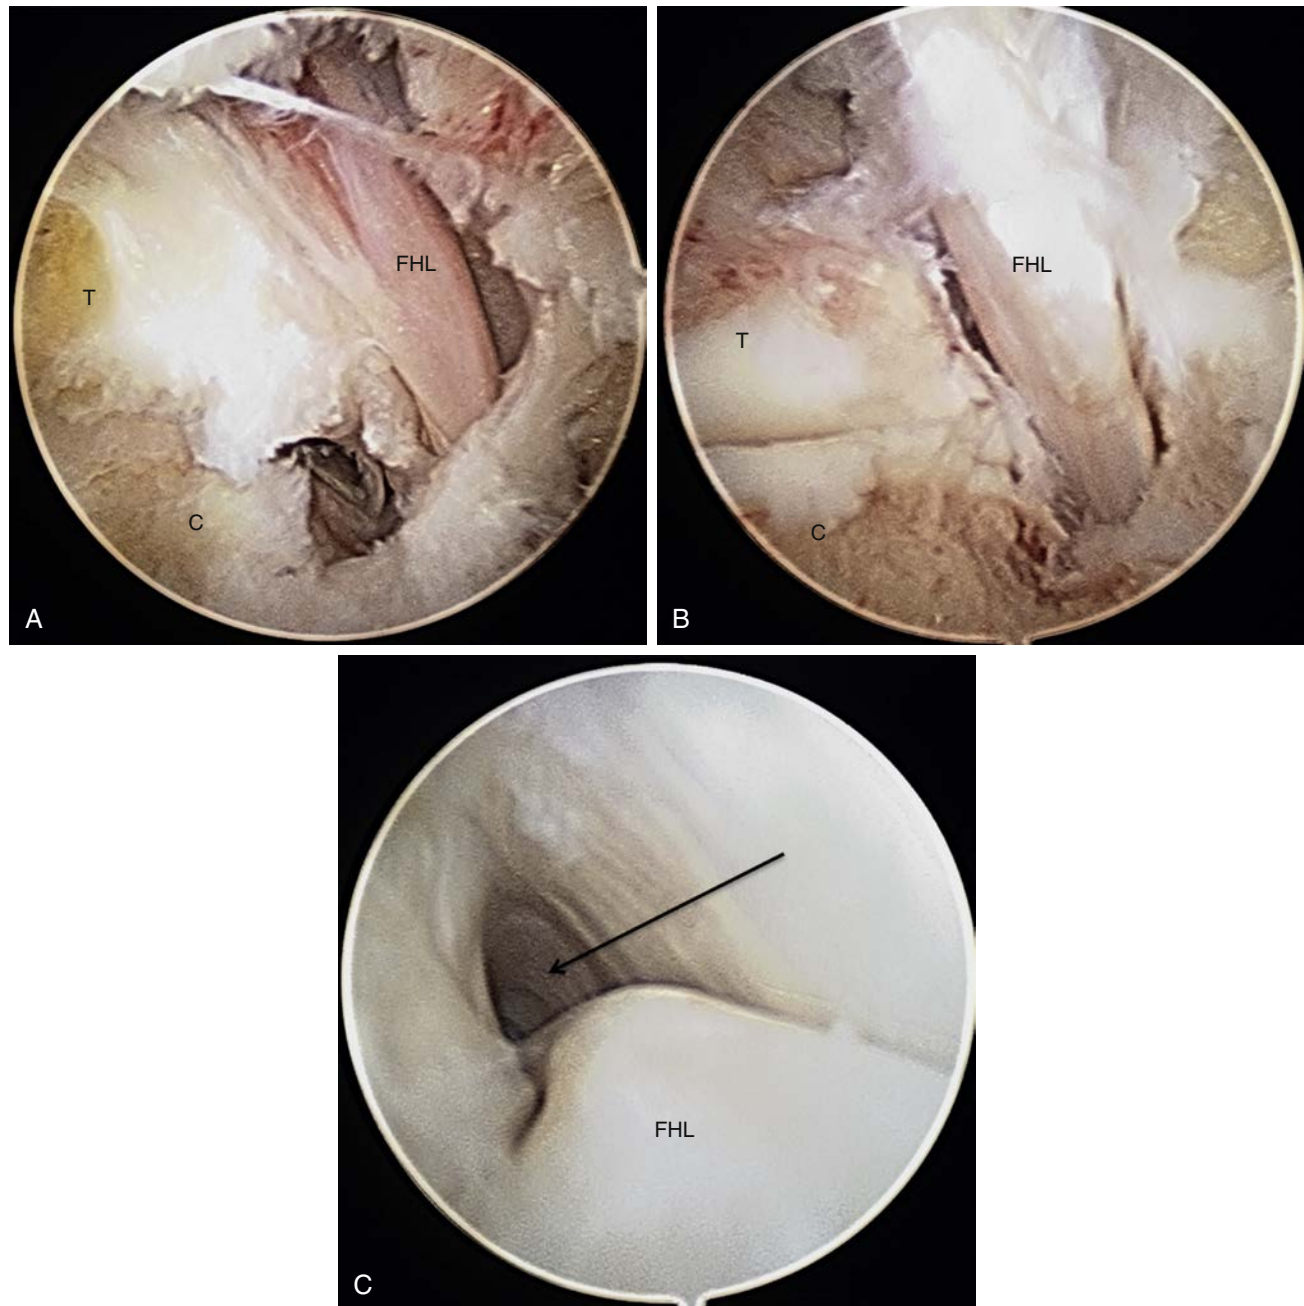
Arthroscopic images of a 23-year-old soccer player who presented with severe posterior ankle pain and exacerbation of symptoms with hallux dorsiflexion. MRI confirmed extensive FHL tenosynovitis (*C* = calcaneus, *T* = talus, *FHL* = flexor hallucis longus). A, Arthroscopic image demonstrating significant tenosynovitis of FHL tendon with the tendon enclosed in hypertrophied inflamed synovium. B, Image after FHL tenosynovectomy and debridement revealing properly oriented tendon fibers free of tears. C, FHL tendon was traced all the way down in its tunnel to ensure complete excision of tenosynovitis and exclusion of tears in the tendon proper (arrow = fibro-osseous tunnel).
